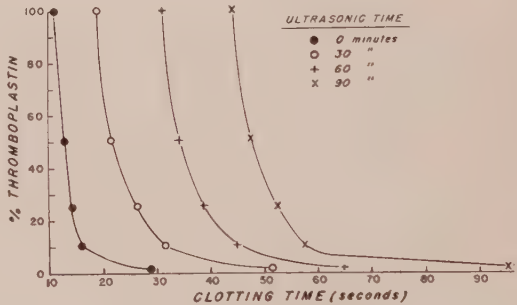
Dilution curves of ultrasonically treated human brain thromboplastin.
